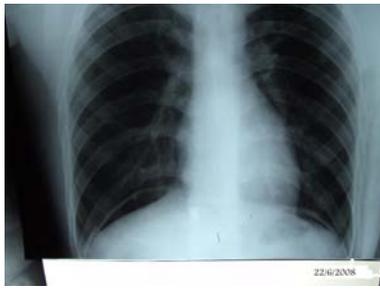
Chest X-ray showing air under diaphragm bilaterally
